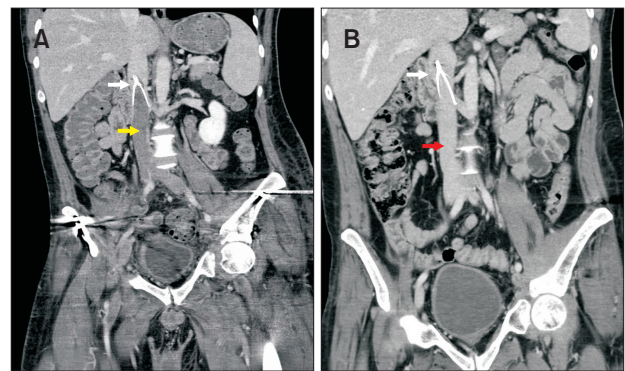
(A) Computed tomography (CT) coronal image showed inferior vena cava (IVC) filter (white arrow) and IVC thrombosis (yellow arrow). (B) Follow-up CT image showed completely resolved IVC thrombosis (red arrow) and IVC filter (white arrow).
